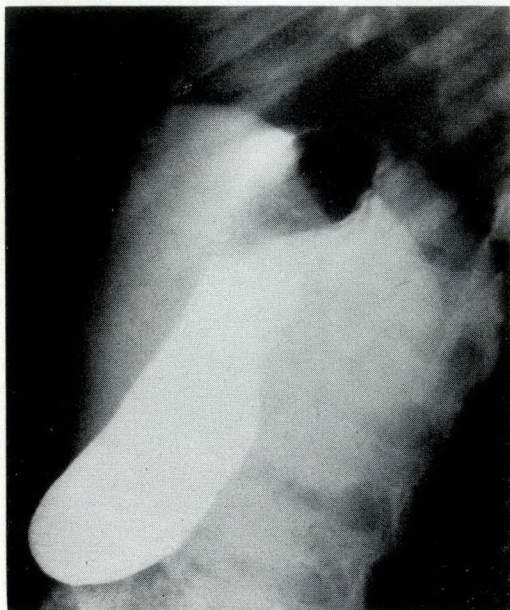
Post-traumatic pancreatic pseudocyst. Postoperative (four weeks) lateral roentgenogram following ingestion of Gastrografin.
